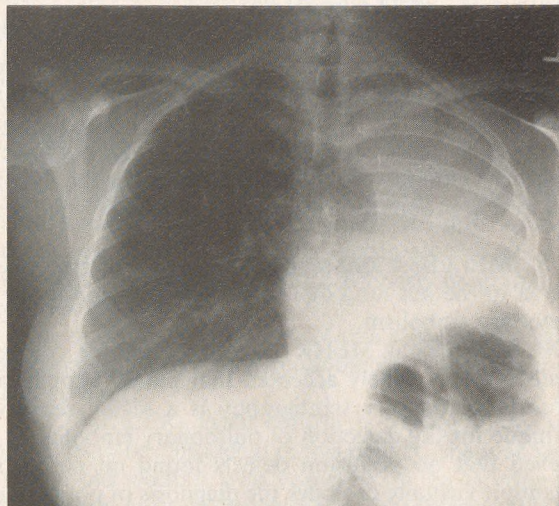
Chest x-ray film obtained the next morning after instituting metaproterenol and acetylcysteine breathing treatments. Note still considerable loss of volume, as shown by the persistent elevation of the left hemidiaphragm
